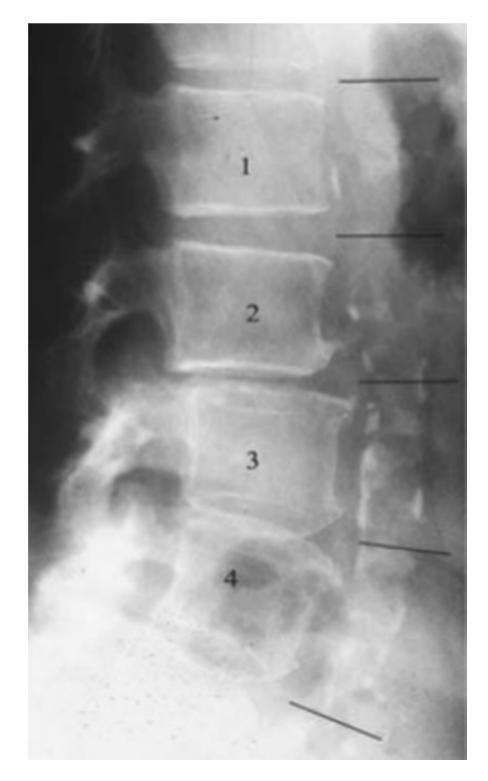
Lateral lumbar radiography of aorta
